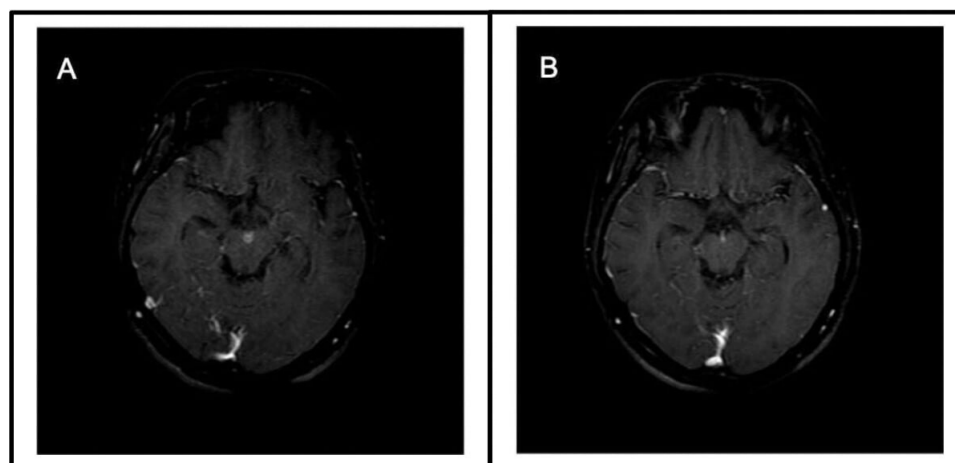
MRI findings of selected patients. Axial T1-weighted MRI of patient 3 that shows focal ring-shaped enhancement in the interpeduncular cistern (A), which reduced on follow-up (B).
